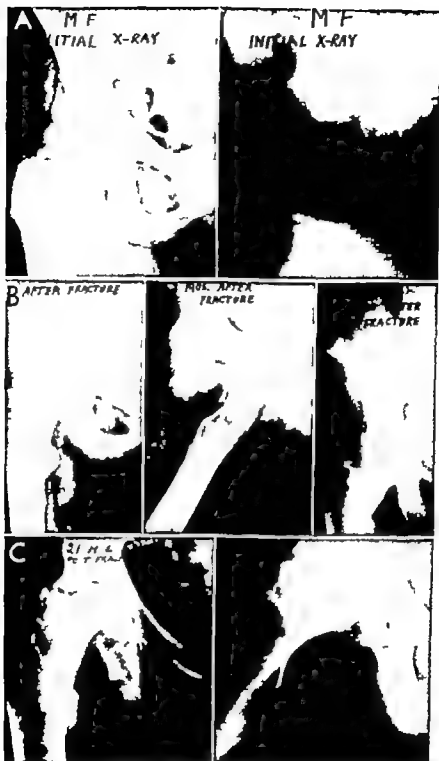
Good quality of the x-ray films is important. A, hip fracture assumed to be favorably impacted, but opinion was based on these films of poor quality B 3 months after injury the patient continued to have pain Again the x ray films were of poor quality C, 21 months after injury the films revealed localized aseptic necrosis. Good detail in the early films may have revealed that this fracture was impacted into too great a valgus position
